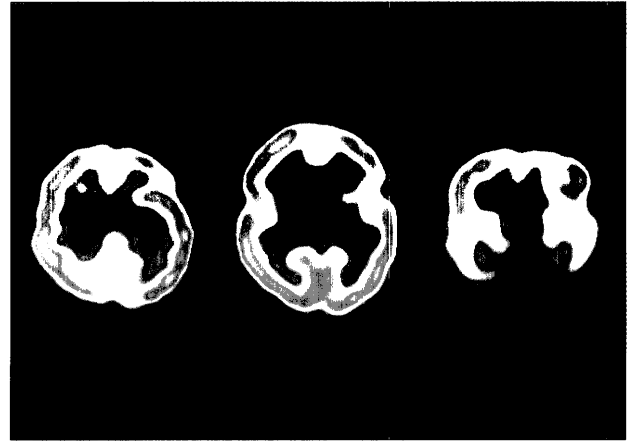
Single photon emission computed tomography study with ^{99m}Tc -ECD.
